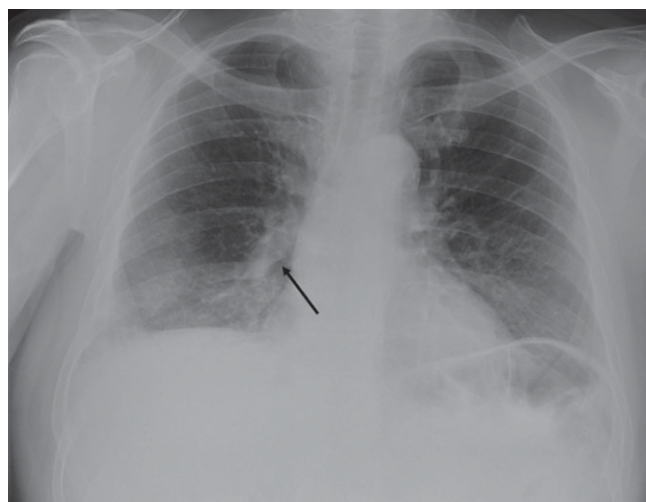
Chest radiograph (posterior-anterior view) showing an enlarged right descending pulmonary artery (black arrow) (Palla's sign).
